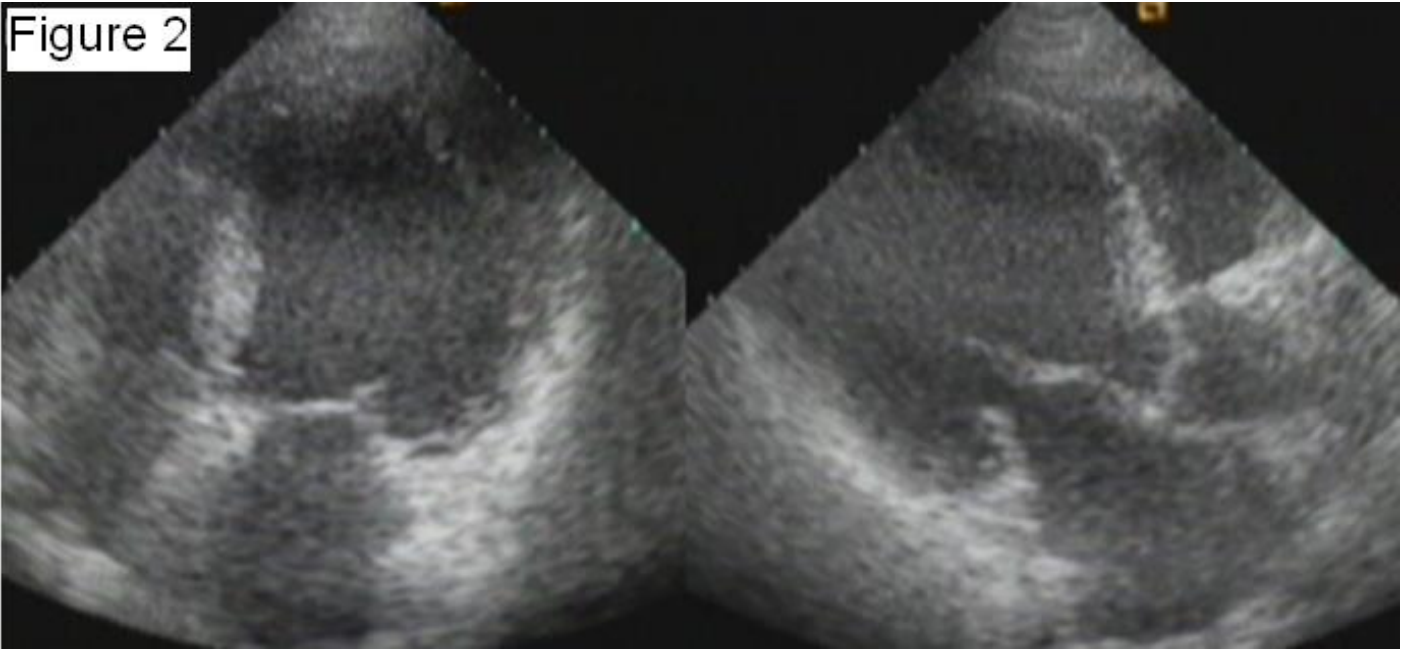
The echocardiography showed that the mass was disappear in the left ventricle after two weeks
